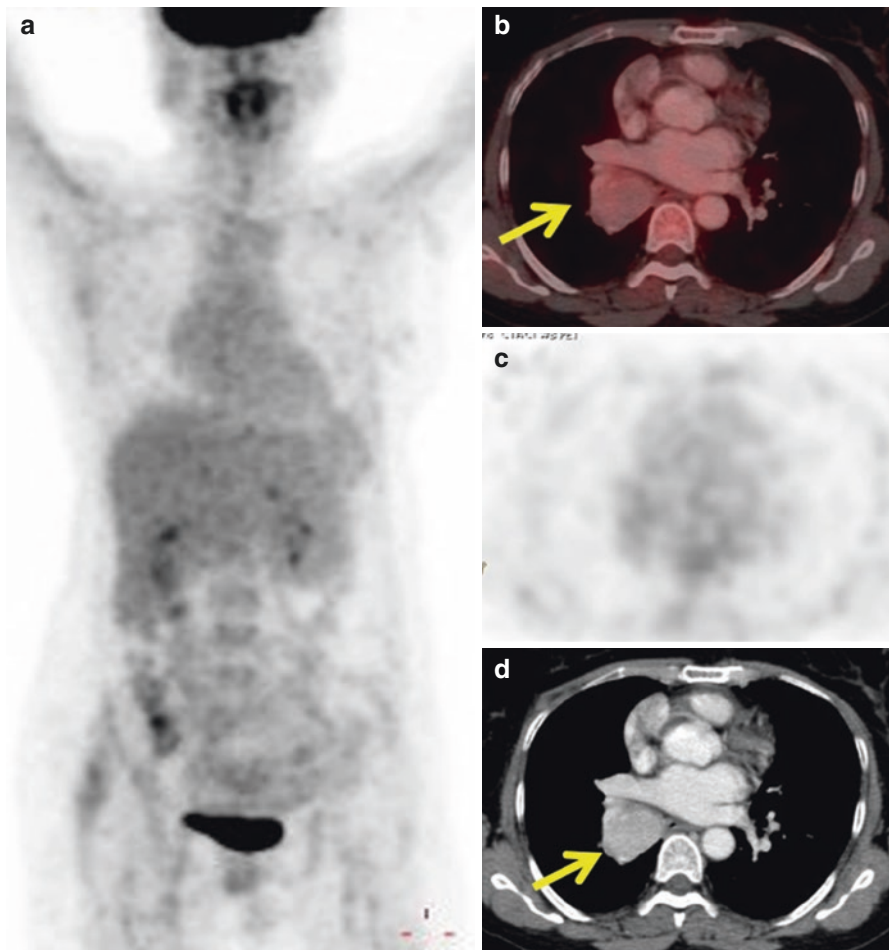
Whole-body FDG PET/CT scan of a 52-year-old lady with right infracarinal mass involving the right lower lobe bronchus. No FDG uptake is noted in the lesion (a and arrow in the transaxial images b–d). Biopsy of the lesion was a carcinoid tumor. A ^{68}Ga -DOTANOC study done subsequently showed intense uptake in the lesion typical of low-grade carcinoids
